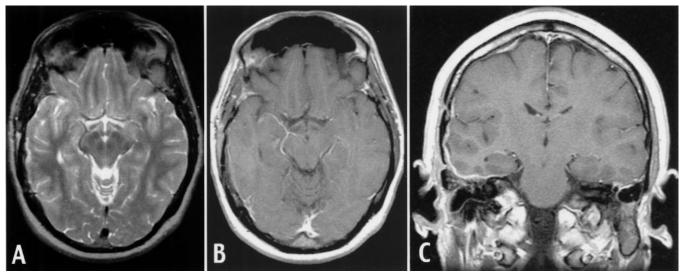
MRI scan after 4 months of treatment. A. Axial T2 weighted image showing normal white matter and grey matter with resolution of pretreatment vasogenic edema. B. Axial T1 weighted image showing slight residual right-side dural enhancement. C. Coronal T1 weighted image showing a significant reduction in dural, pial arachnoid, and parenchymal enhancement. Subsequent scans (not shown) also revealed gradual clearing of dural enhancement.
